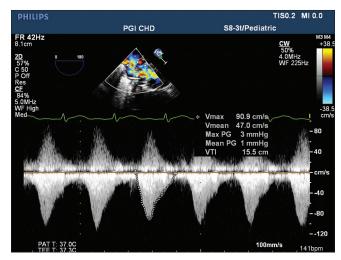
A continuous wave doppler placed in the pulmonary venous baffle (PVB) after surgical correction of PVB stenosis showing a peak gradient of 3 mm Hg and mean gradient of 1 mm Hg
